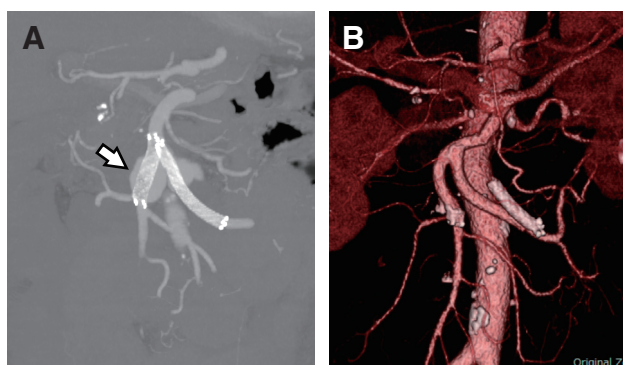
Case 1: pre- and post-operative CT. (A) CT showing the superior mesenteric artery aneurysm and stents (arrow). (B) 3-dimensional CT after the infective superior mesenteric artery aneurysm resection and vascular reconstruction using an expanded polytetrafluoroethylene graft. CT: computed tomography
